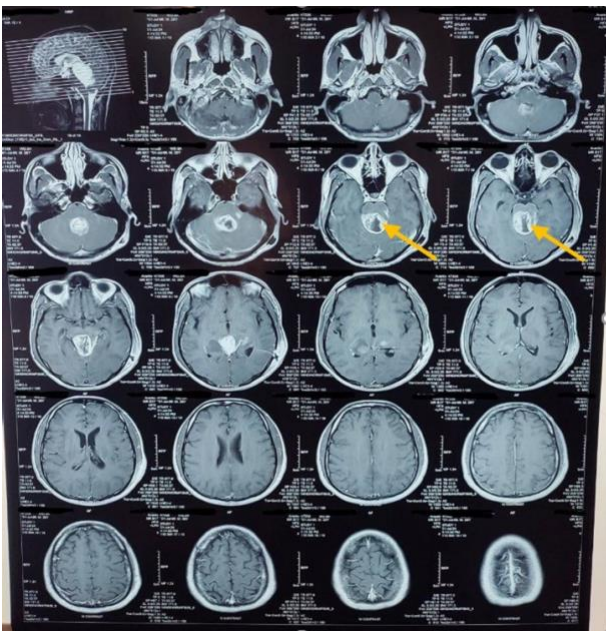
MRI in the transverse plane showing the tumor in relation to the tectal plate. (Yellow arrows)
